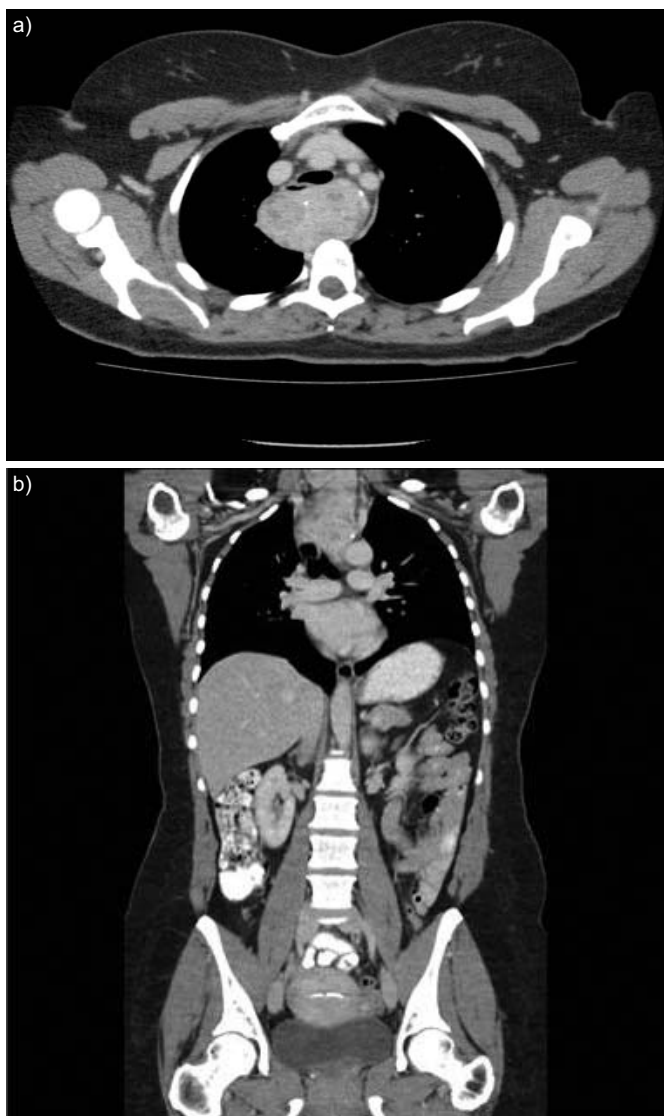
a) Contrast-enhanced computed tomography (CT) showing a large retrotracheal and retro-oesophageal mass with heterogeneous enhancement and punctate calcification. b) Coronal view of the thorax CT showing mediastinal mass in continuity with left lobe of thyroid gland.
